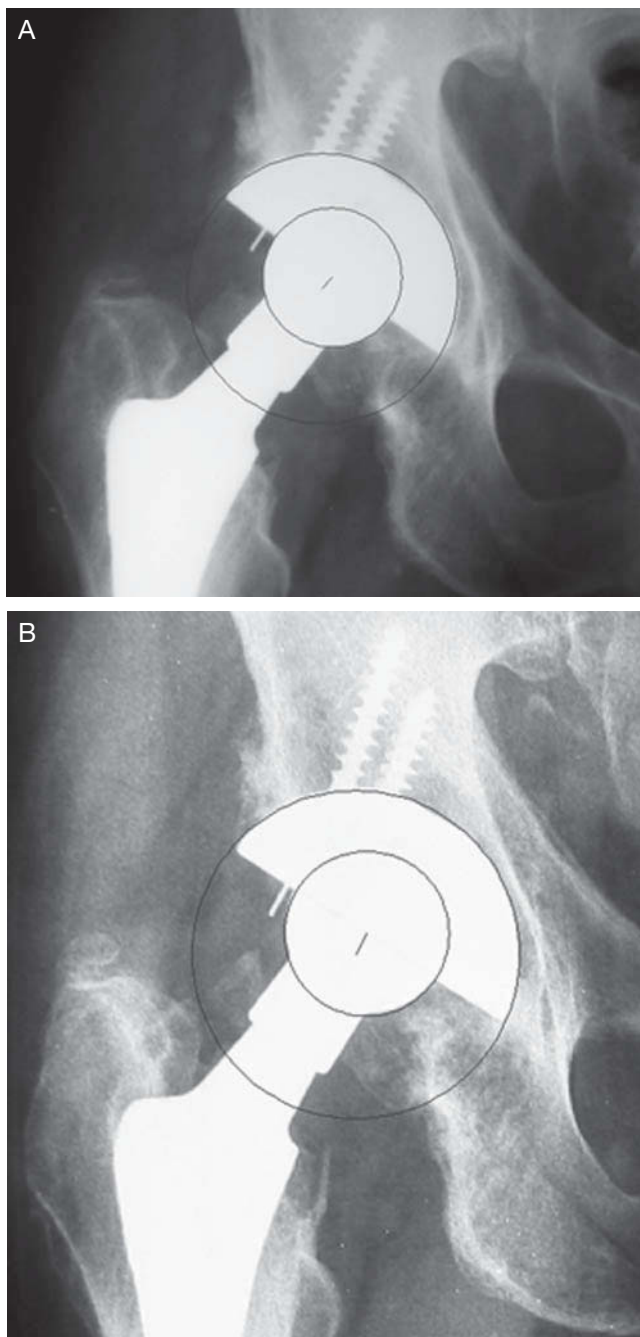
52 year-old male. Body mass index (BMI): 25.71. A: Radiograph at 6 weeks. Initial distance between centers: 2.54 mm. B: Follow-up: 9.92 years; final displacement between centers: 4.34 mm; linear wear: 1.80 mm; annual wear, 0.18 mm.
